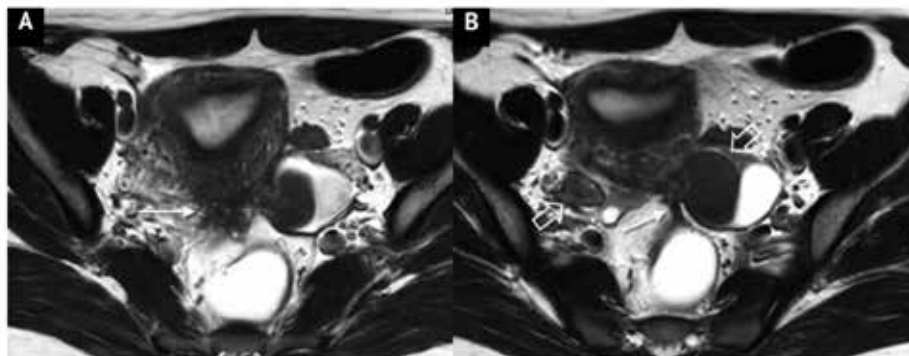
Representation of an implant on the posterior uterine side with adhesions to the ovaries and rectal fascia. Axial T2-weighted images. Endometriosis implant identified on the posterior surface of the uterus in the uterine torus region [(arrow in image A)]. Both ovaries [(empty arrows in image B)] are located behind the uterus with adhesions between the uterus and ovaries, and an endometrioma in the left ovary. Additionally, in this case, a fibrous band can be seen due to adhesions between the anterior surface of the rectum and the uterine implant [(long arrow in B)].⁹
